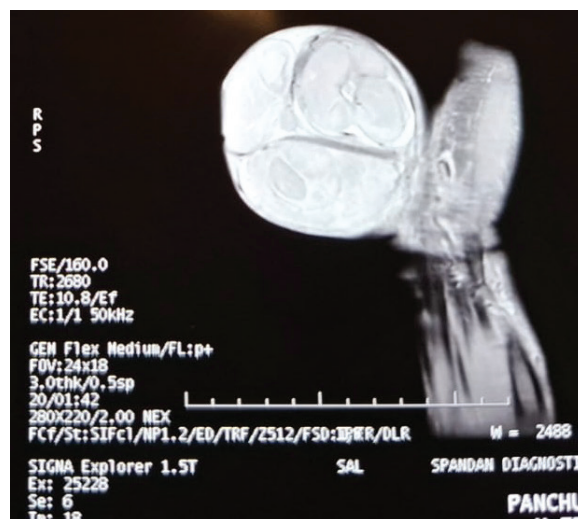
MRI of the swelling at the palmar aspect of left hand.
